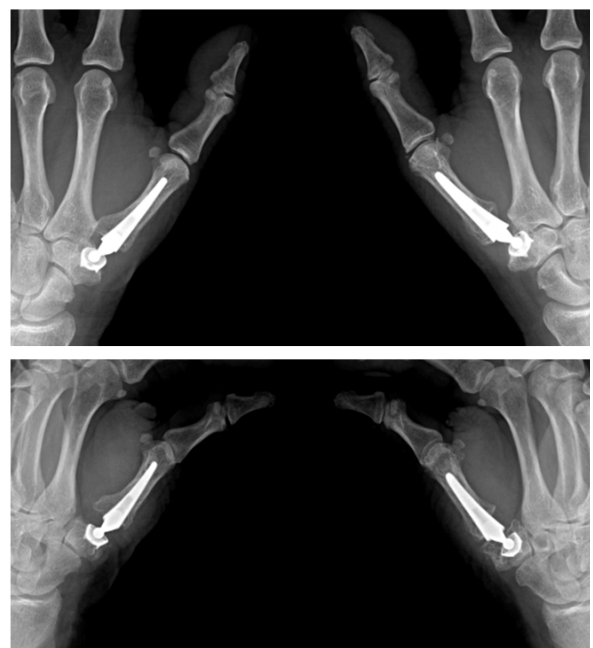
Postop. X-ray control. Appreciate that the major resection of the neck provides more space between the base of the first metacarpal and the base of the second metacarpal and the trapezium, avoiding bone impingement, which in some movements could cause dislocation of the prosthesis.
